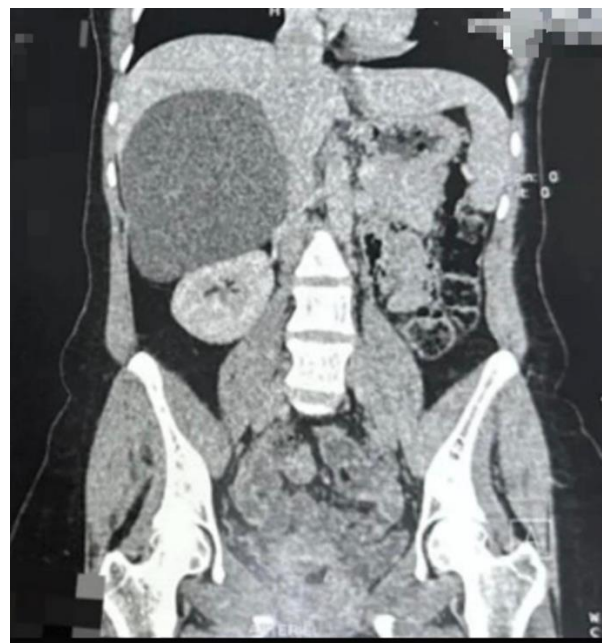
Frontal CT scan from the TAP c+ CT, showing a cystic mass exerting a mass effect on the liver without invasion or irregular enhancement, with displacement of the slightly ptotic right kidney downward; the adrenal glands are of normal size and density. (Department of Visceral Surgery 'I', HMIMV, Rabat, MOROCCO)
